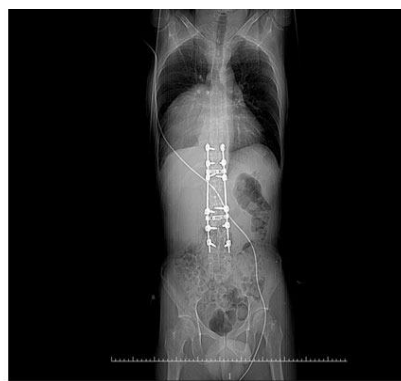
Postoperative thoracolumbar computed tomography
